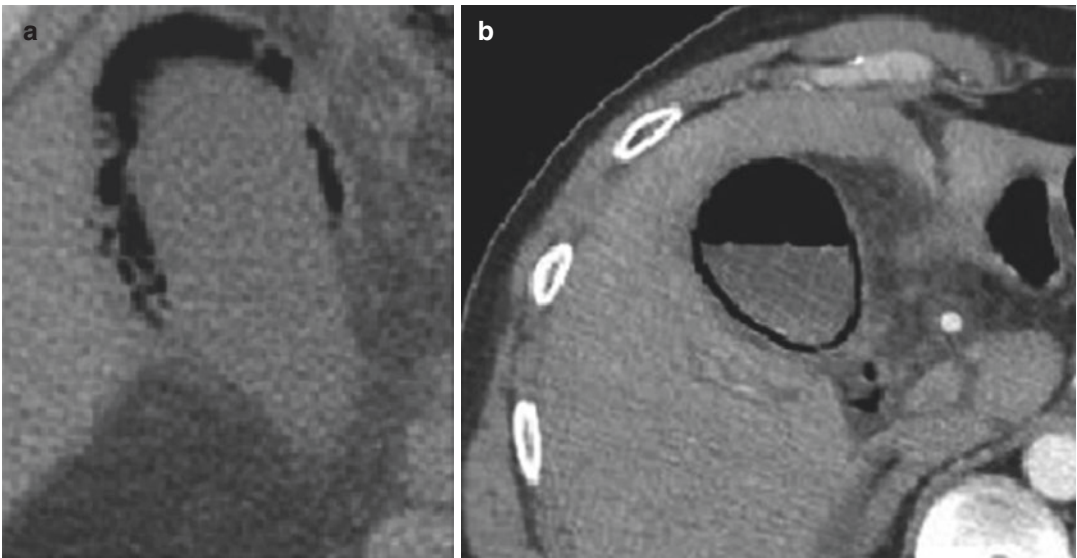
(a, b): CT scan Emphysematous cholecystitis
